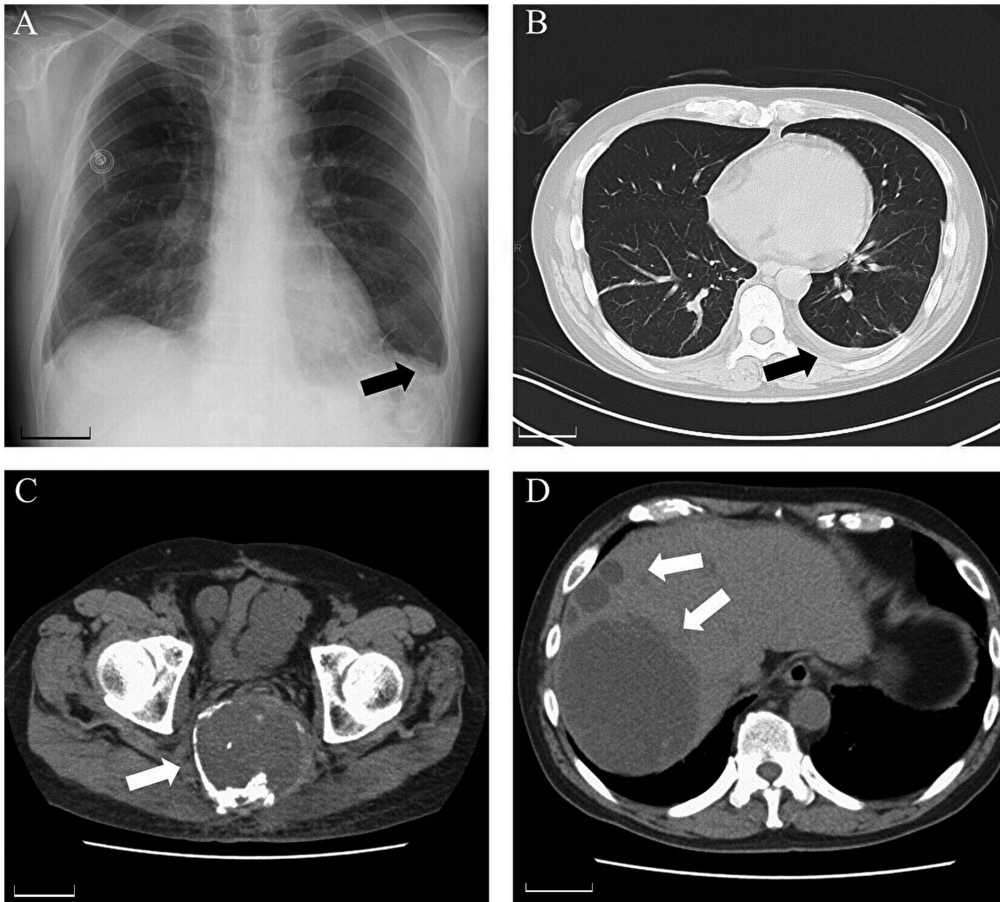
Imaging findings on admission. Scale bars, 5 cm. (A) Chest X-ray revealed a blunt left costophrenic angle. (B) Thoracic computed tomography showed left pleural effusion with no signs of pneumonia. (C) No significant progression was observed at the primary site in the sacrum. (D) No significant progression was observed at the metastatic sites in the liver.
